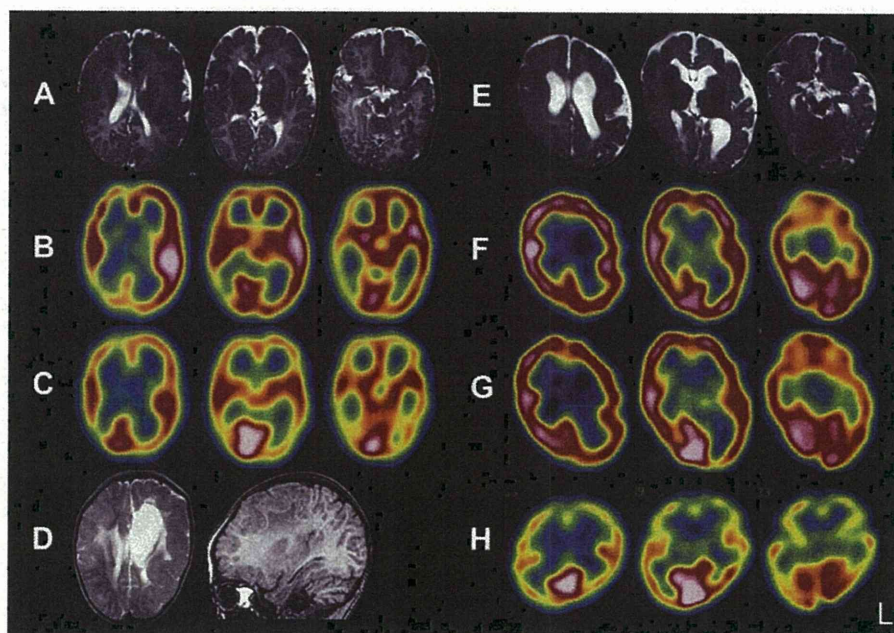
MRI and ¹²³I-iomazenil SPECT images of the 2 patients and a control subject. (A, E) T2-weighted images and (D) T2-weighted axial image (left) and T1-weighted sagittal image (right). (A–D) case 1: (A, C) 2 months, (B) 19 days, and (D) 29 months. (E–G) case 2: (E, F) 6 months, and (G) 17 months. (H) Control SPECT images of a 5-month-old infant with benign infantile convulsions. MRI, magnetic resonance imaging; SPECT, single photon emission computed tomography.
